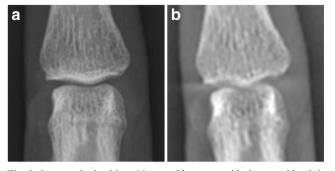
Images obtained in a 66-year-old woman with rheumatoid arthritis. Radiograph (a) and tomosynthesis (b) images of the third proximal interphalangeal joints were scored as 0 and 2, respectively, according to the Sharp/van der Heijde method for joint space narrowing. The joint space narrowing is better depicted with tomosynthesis than with radiography
